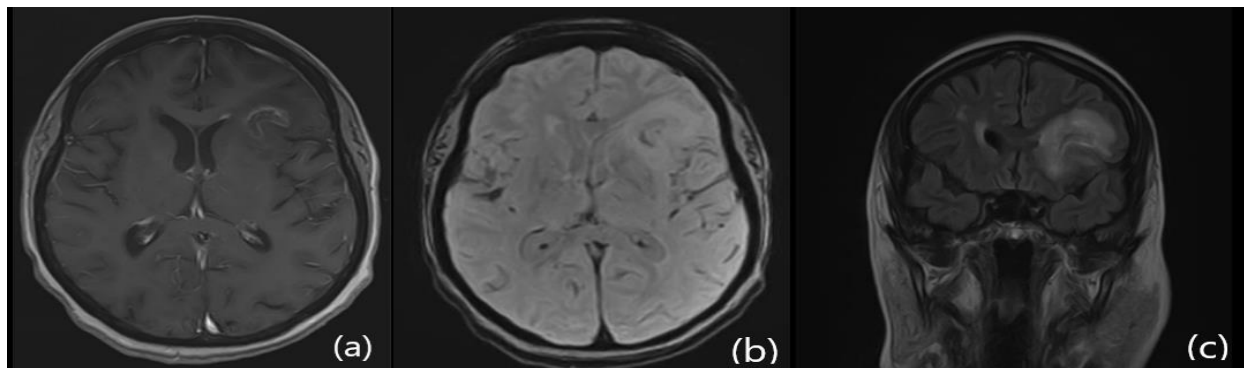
MRI brain with contrast. (a) T1 image showing a peripheral enhancing lesion with meningeal enhancement. (b) T2/FLAIR image showing abnormal signal intensity areas in the left frontal lobe and left basal ganglia showing hyperintense signals with intralesional T2/FLAIR crescentic hypo-intensity demonstrating heterogeneous enhancement and patchy diffusion restriction. (c) T1 coronal view showing the same lesion with perilesional oedema.
